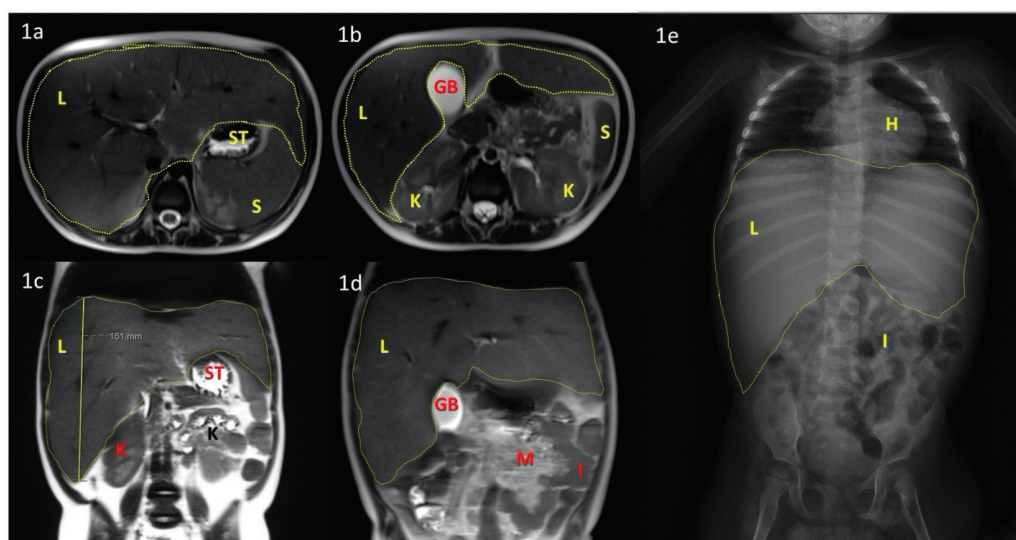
Abdominal MRI and X-ray findings of the patient. a and b) Sagittal upper abdominal T2-weighted MRI slices show massive hepatomegaly, which is occupying both upper quadrants and crossing the midline. c and d) Coronal upper abdominal slices of the same findings, with the liver craniocaudal length reaching 151 mm. e) Abdominal X-ray showed massive hepatomegaly, occupying most of the upper quadrants.
